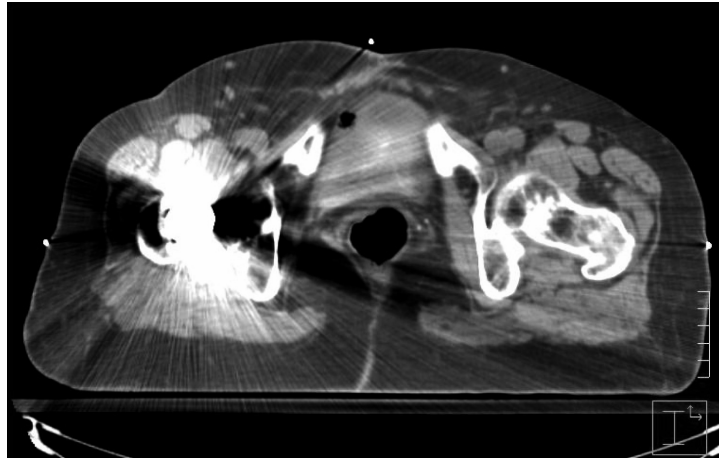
CT Scan of a patient with an artificial hip.
